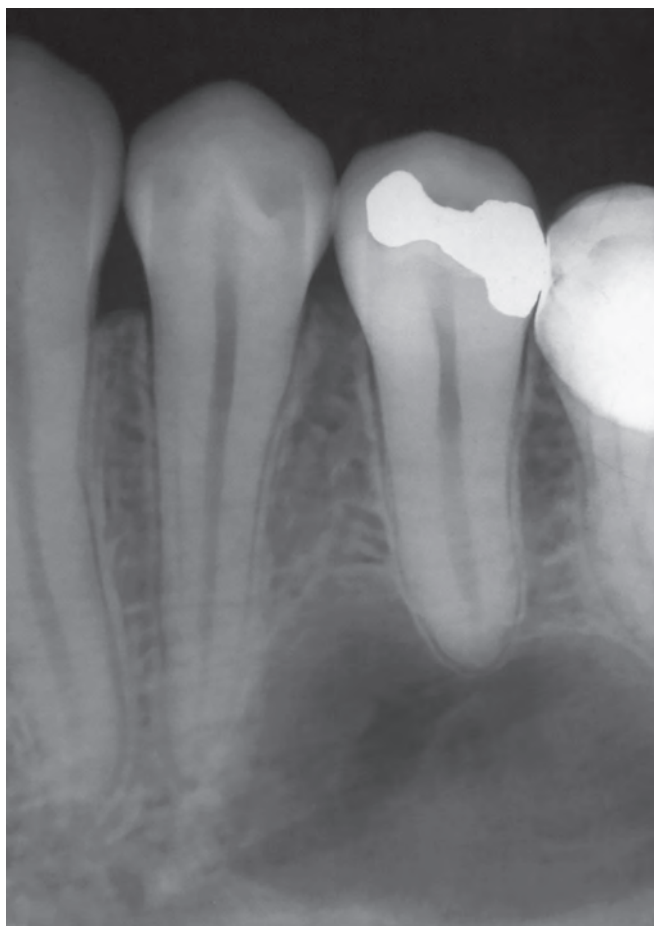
Simple bone cyst in periapical region of premolars. Note root contour without loss of lamina dura.
